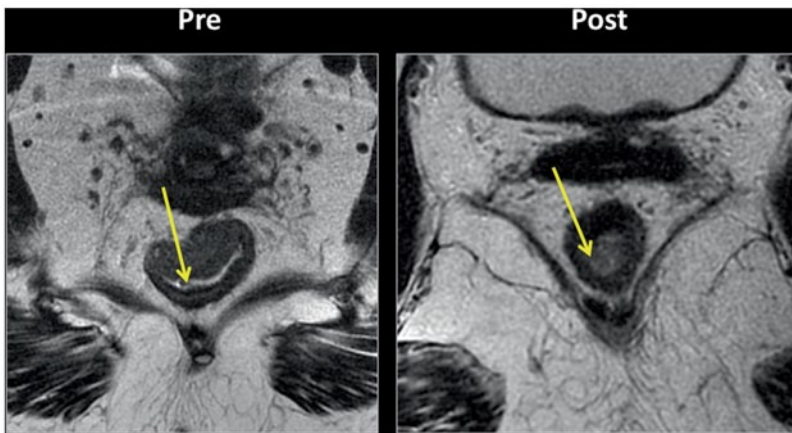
Pelvic magnetic resonance imaging (*MRI*) findings demonstrate complete response after neoadjuvant chemoradiotherapy
